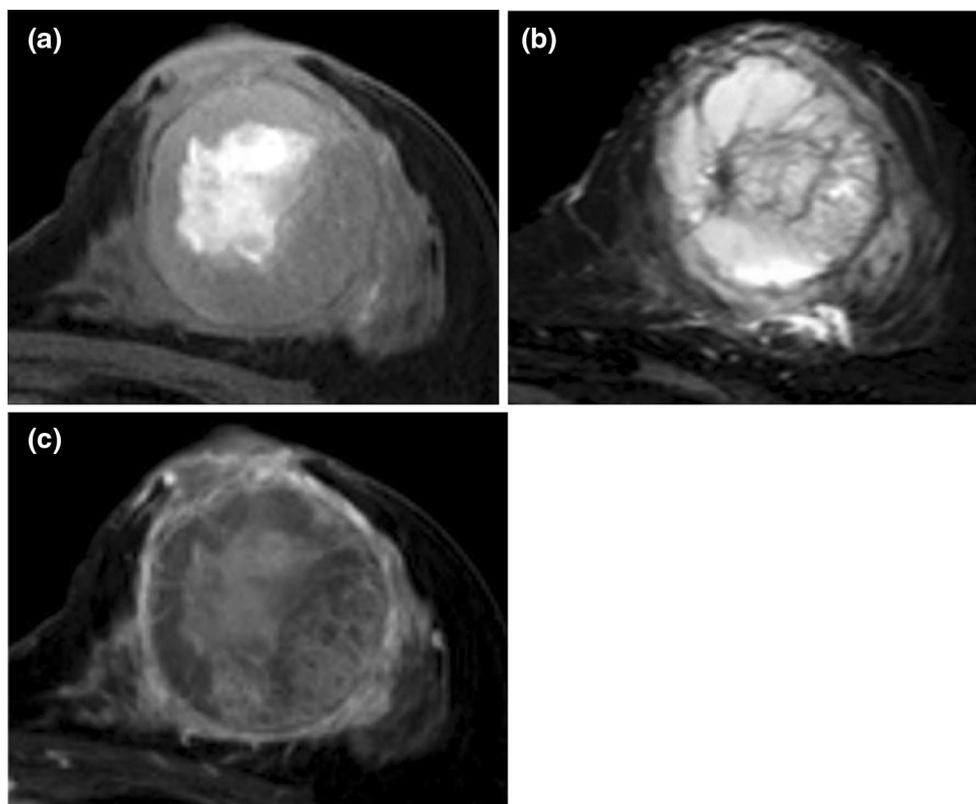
Magnetic resonance imaging showing a well-demarcated, 5-cm tumor in the left breast. A high-intensity area on T1- (a) and T2-weighted (b) imaging suggested hemorrhaging. The tumor had a fibrous capsule that was enhanced gradually after administration of a radiopaque dye (c)
